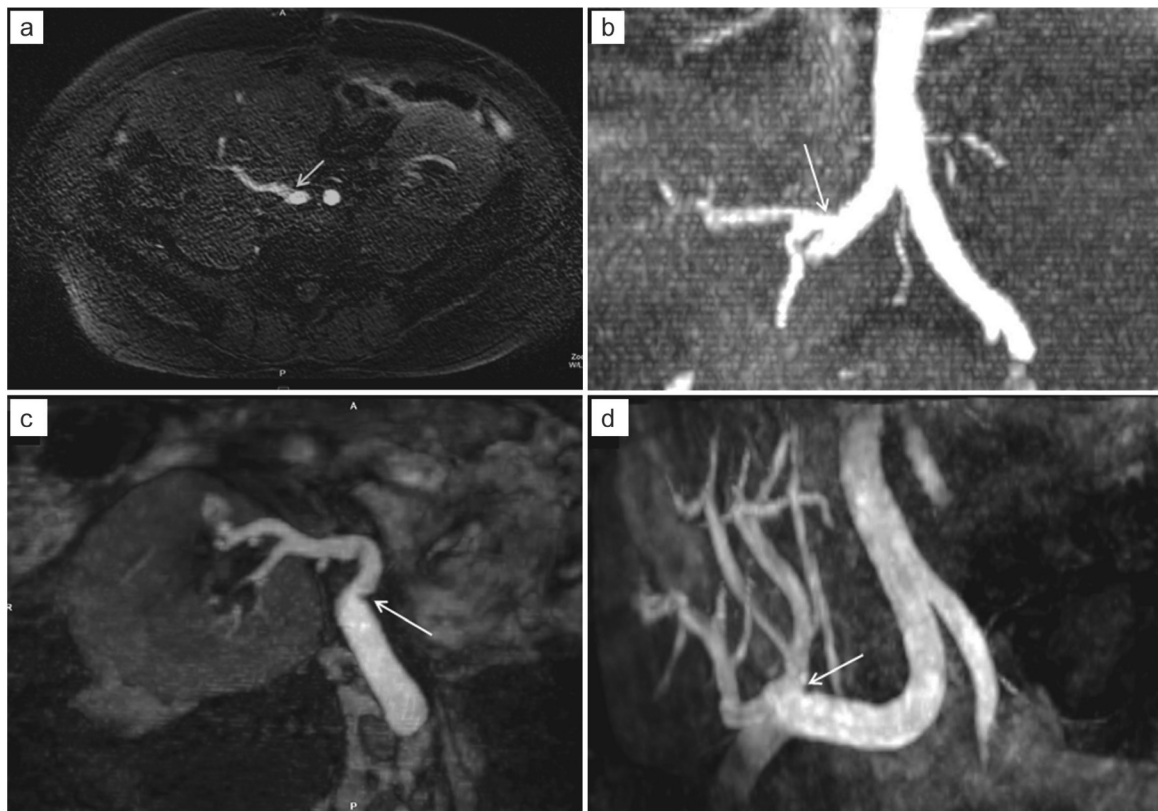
Normal QISS MRA and reformat in a 48-year-old male with a 1-year history of right lower quadrant kidney transplant that presented with mild renal dysfunction (GFR = 48) and abnormal Doppler ultrasound (a and b); Normal appearance of a 3D SSFP MRA reformat in a 60-year-old female with a 3-year history of right lower quadrant kidney transplant presented with renal dysfunction (GFR = 32) and abnormal Doppler ultrasound (c and d).
